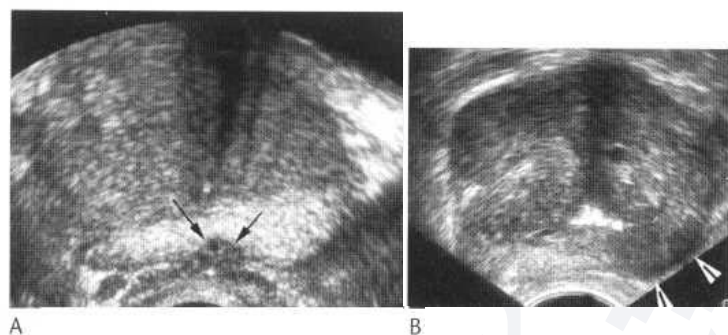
Transrectal ultrasound (transverse images) on patients with prostatic cancer. (A) shows a tiny peripherally placed carcinoma as a hypoechoic nodule (arrows) easily seen against the remainder of the normal hyperechoic peripheral gland. (B) shows a larger area of reduced echogenicity (arrowheads) replacing much of the left peripheral gland and showing an ill-defined infiltrative margin towards the adjacent central gland. It currently, however, still appears confined by the prostatic capsule. (C) shows an extensive prostatic cancer seen as a sheet of echo-poor material that has replaced the normal peripheral gland and is infiltrating anteriorly into the central gland.
